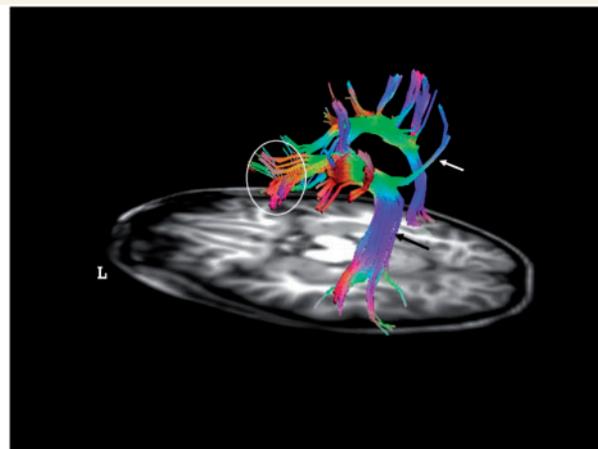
The superior longitudinal fasciculus. Diffusion Tensor Imaging-fibre tractography of the superior longitudinal fasciculus of both sides, over an axial T1 MRI-cut at the level of the temporal lobe. Left lateral view. Tracts are directional colour coded for better tracking. Blue colour indicates top–down; green indicates anterior–posterior and red indicates right to left directions. Reversed directions are encoded within the same colours. White arrow = parieto-frontal fibres (dorsal part of the superior longitudinal fasciculus); black arrow = AF. Within the circle, the opercular endpoint is depicted. Notice the asymmetry of the fibres for more prominent left AF. (Images courtesy of Miami Children's Hospital, Department of Radiology).
